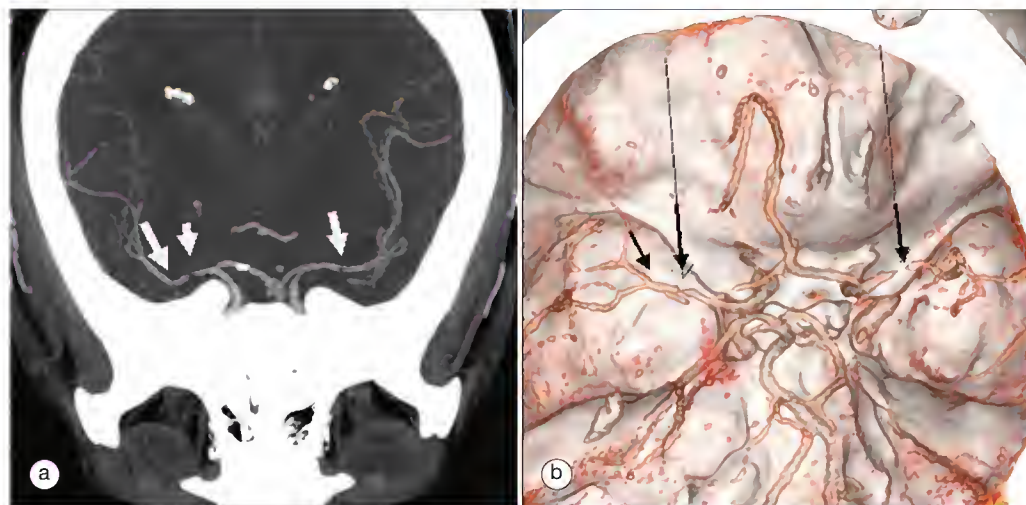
Magnetic resonance imaging (a) and computed tomographic angiography (b) of cerebral artery branches with focal arterial narrowing (arrows) in cerebral vasculitis. The inflamed vessels may become narrowed, occluded, and thrombosed and are associated with tissue ischemia and necrosis in the territories of the involved vessels.
